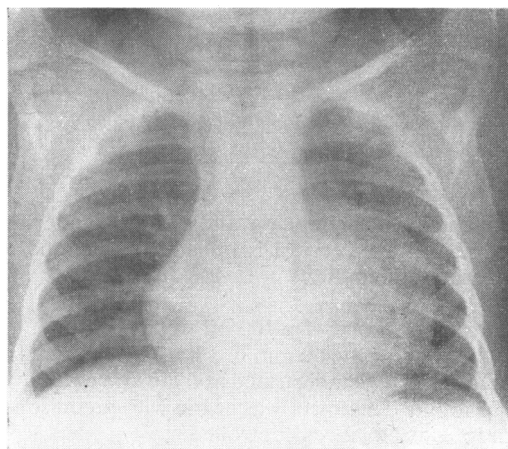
Chest X-ray, November 1961, showing globular enlargement of left cardiac border
